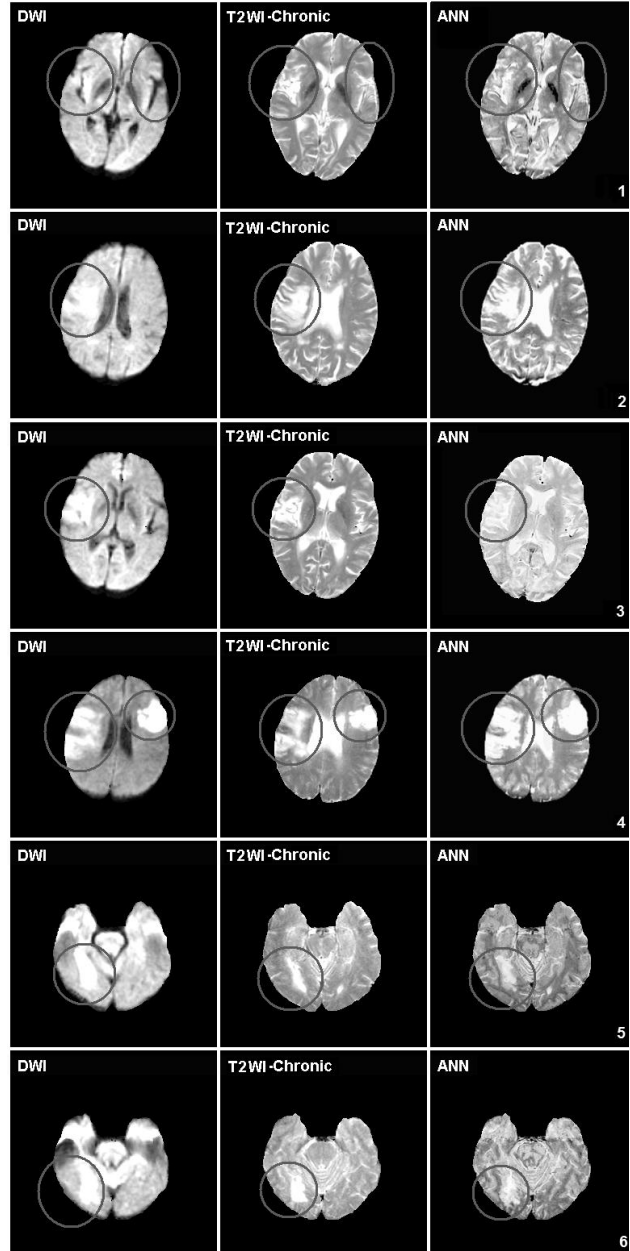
Examples of ANN-produced images in 6 exemplary MRI slices. Left column: DWI in acute study. Middle: outcome T2WI. Right: ANN predicted outcome from acute image set. Image sets 1, 2, 3, and 4 were members of the training set. Image sets 5 and 6 were not members of the training set.
